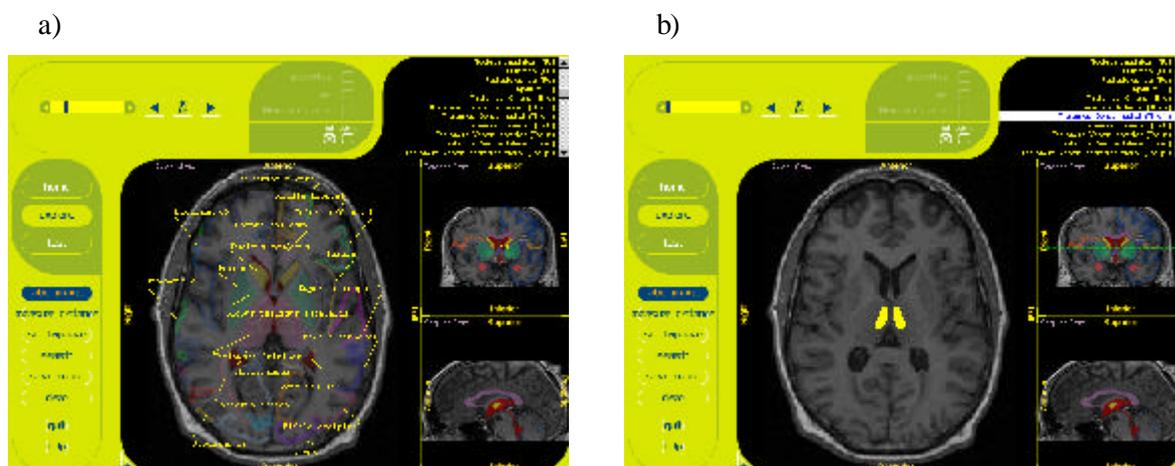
The *Cerefy Student Brain Atlas*: a) interactive labeling of brain structures on the orthogonal MRI images; b) localization of the cerebral structure selected from the anatomical index (the thalamic dorso-medial nucleus is highlighted).
